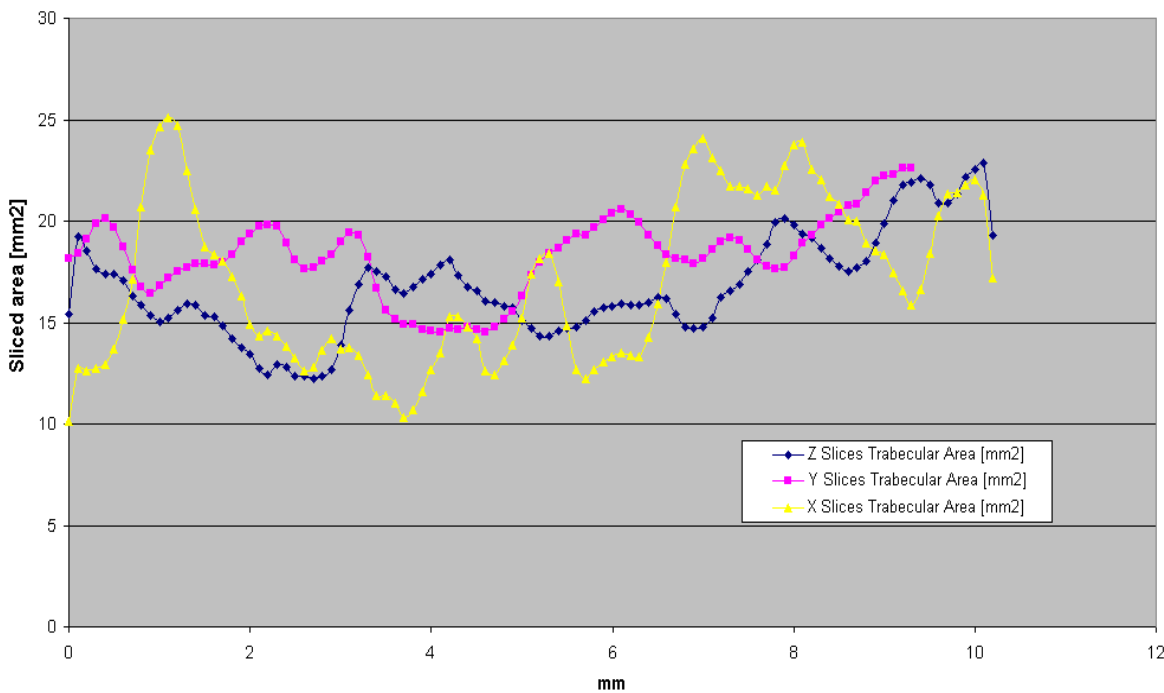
Cubic  $\mu$ CT sample: sliced area distributions along X, Y and Z
